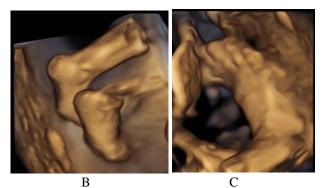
A. Normal HD and B. 3D ultrasound images of a 25weeks old fetal's feet. C. Normal foot in a 29weeks 5days fetus
